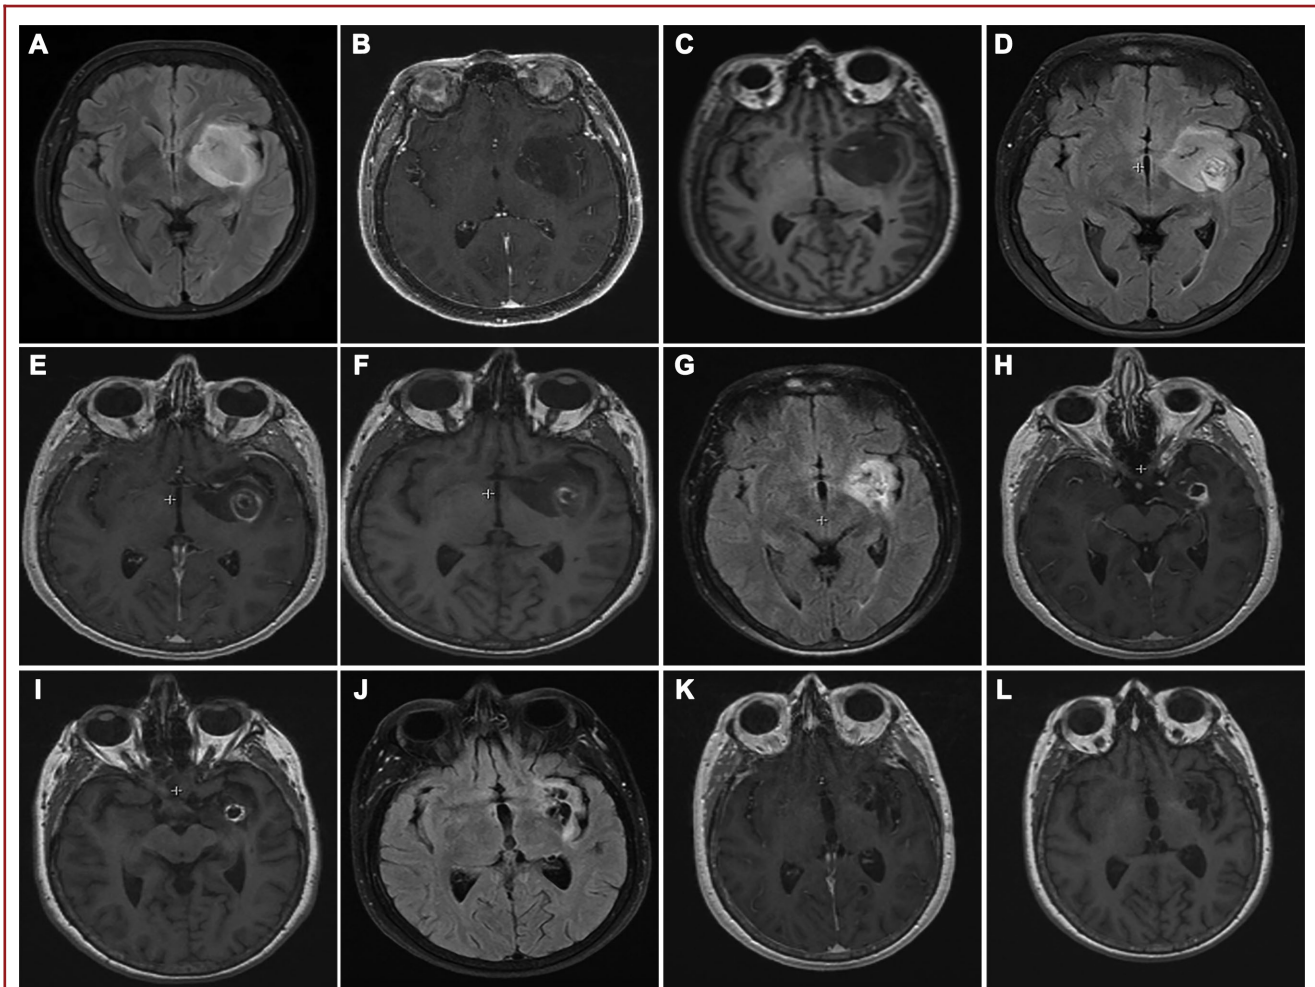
FLAIR, T1 with, and T1 without images demonstrating treatment of left insular oligodendroglioma. Lesion size and FLAIR signal noticeably reduce in size from preoperation A-C, 60 d after stage I ablation D-F, 60 d after stage II ablation G-I, and 2 yr after stage II ablation J-L.
